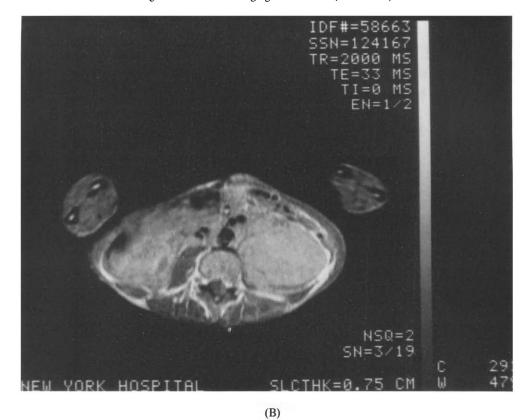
Axial images at the level of the aortic bifurcation demonstrate the inferior extension of the mass. (A) Postcontrast CT image. (Figure continued on overleaf.)
